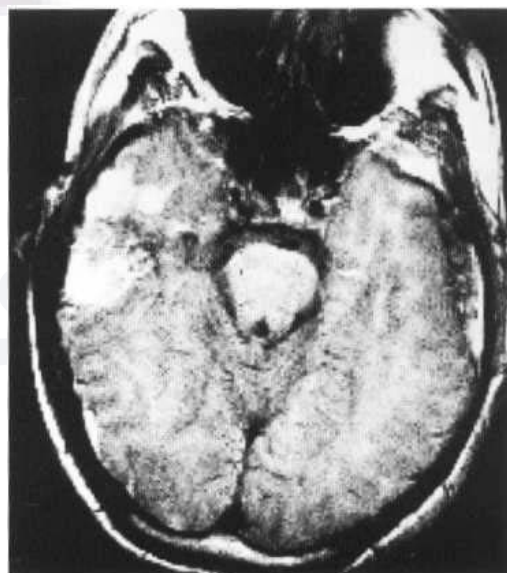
MRI of right temporal lobe contusion (T₂-weighted). There is irregular high signal intensity within the temporal lobe, following trauma to the tempoparietal region of the skull.
